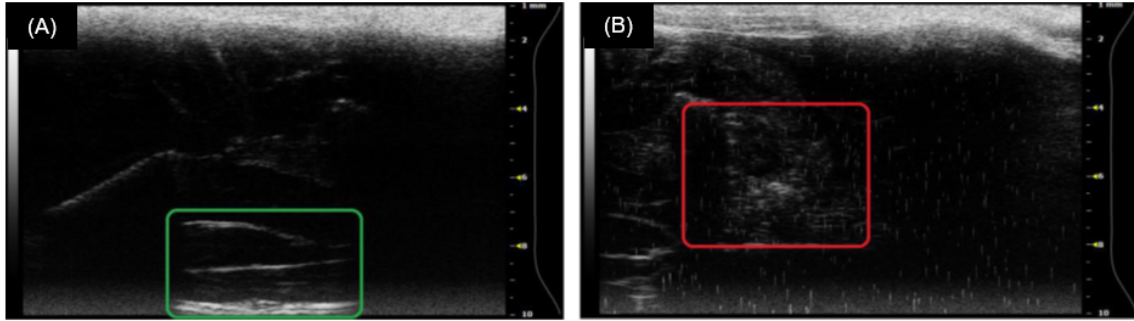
Ultrasound images display (a) healthy muscle fibers and (b) the *in situ* gel system.
